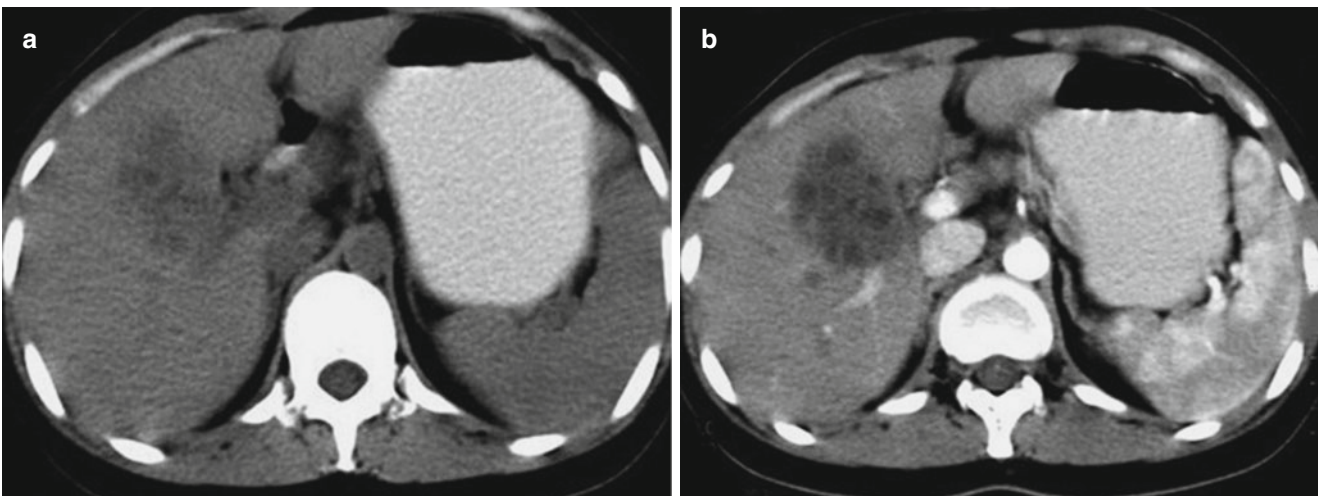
Hepatic hydatid rupture. (a, b) Plain CT scanning demonstrates increased uneven density of intrahepatic cyst with poorly defined boundary. The intrahepatic bile ducts around the lesion are demonstrated to be slightly dilated. The lesion is not enhanced by contrast scanning
